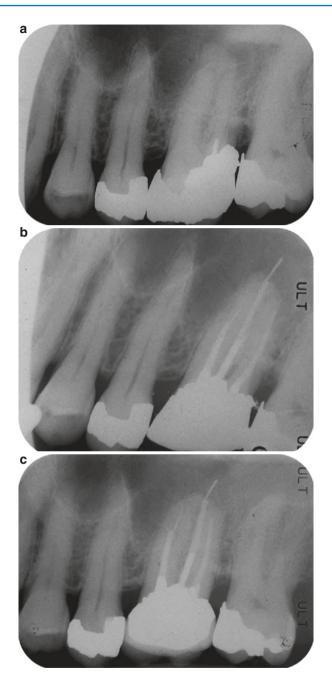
(a) Preoperative radiograph of tooth 26 with calcified root canals and evidence of apical periodontitis around the palatal root. (b) During endodontic treatment, a 25/0.04 taper rotary NiTi instrument was fractured in the mesiobuccal canal. An attempt to remove the fractured instrument with ultrasonics resulted in part of the fragment fracturing off and relocating in the palatal canal and extending beyond the apex. The palatal canal had previously been prepared to a size 60/0.04 taper. (c) Four-year review showed healing
